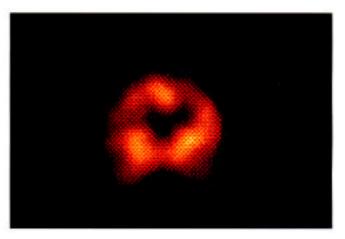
Brain SPECT scan posterior coronal view shows multifocal cortical hypoperfusion in the left and right parietal cortex.
